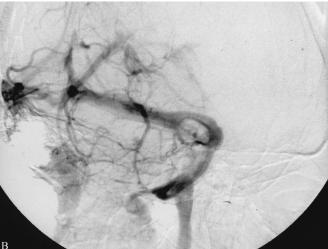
(A) Brain MRI with contrast shows unenhancing lesion in the left transverse sinus. (B) Cerebral angiogram shows a focal smooth filling defect in the left transverse/sigmoid sinus junction with no limitation of the outflow.
